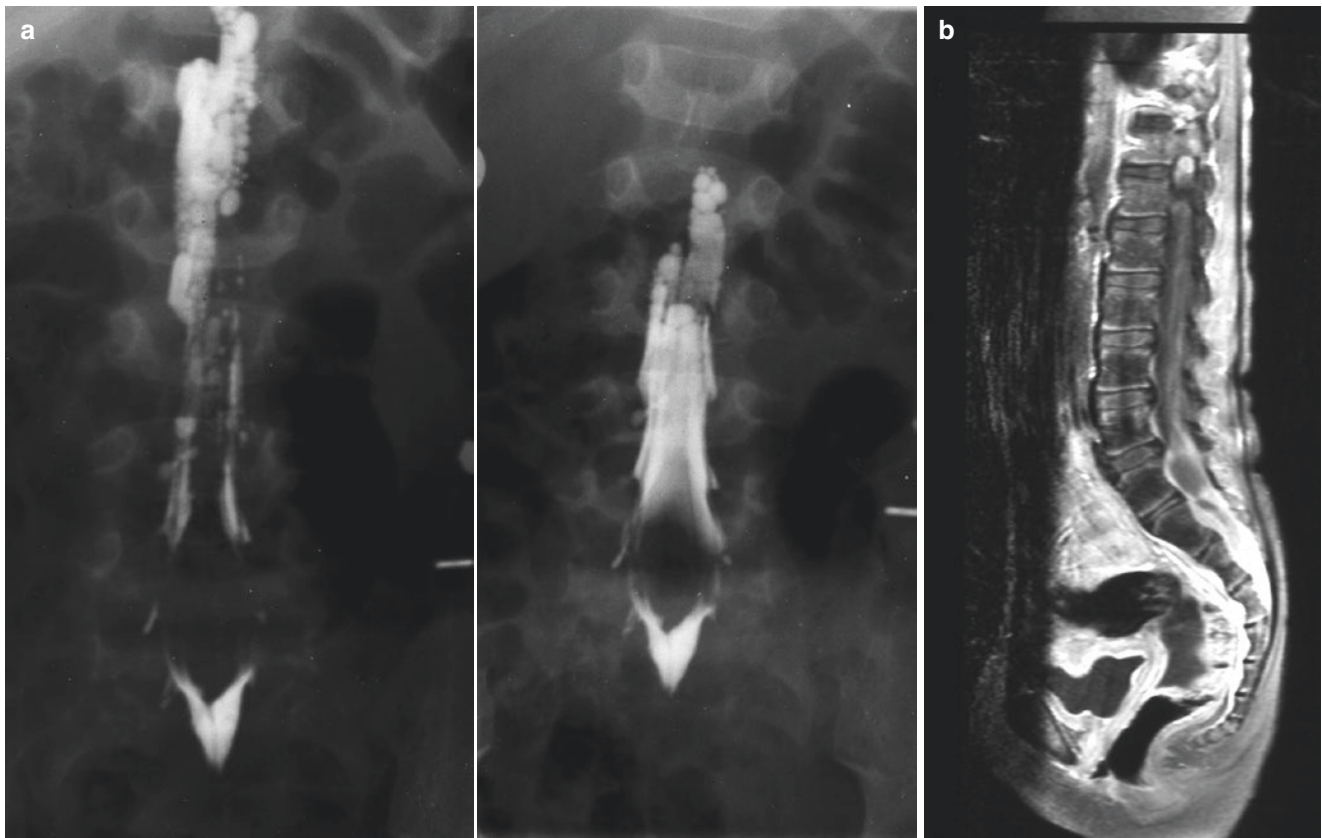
(a) Myelogram spinal lipoma. (b) MRI scan, lateral view of an intraspinal tumour
